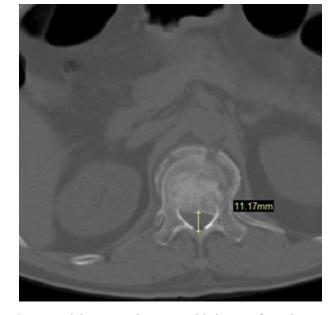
Axial computed tomographic image of a L1 burst fracture at the level of the pedicles, demonstrating technique used to measure the mid-sagittal diameter, the mid-sagittal diameter was 11.17 mm in this sample. (Color version of the figure is available online.)
